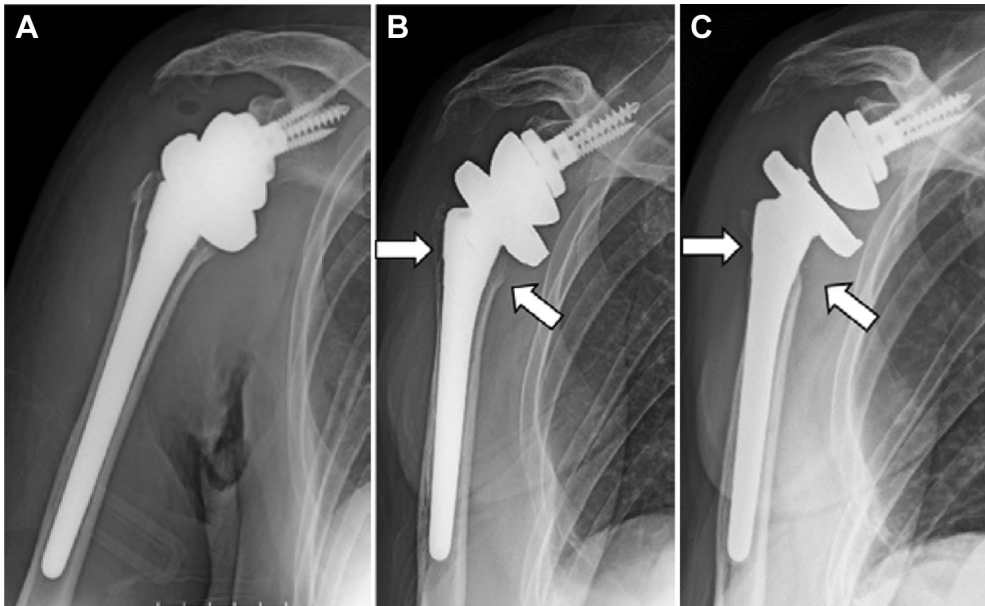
Radiographs obtained immediately (A), at 6 months (B), and at 1 year (C) postoperatively. White arrow, bone resorption area.
